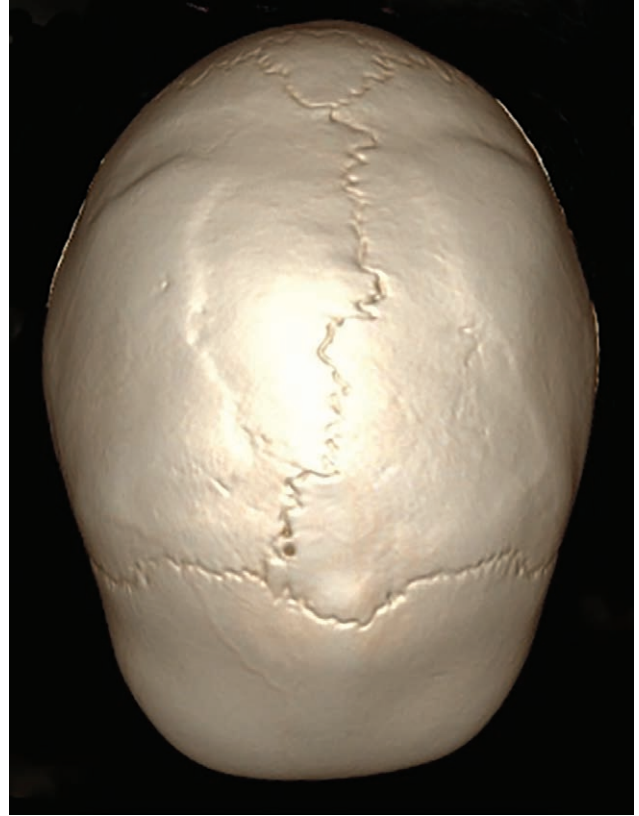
Postoperative CT scan image demonstrating neosagittal suture. CT scan at approximately 2 years postoperatively demonstrates a patent sagittal suture with slight rightward deviation of the anterior sagittal suture at its confluence with the coronal suture. There is age-appropriate patency of the coronal and lambdoid sutures, in addition to closure of the metopic suture.
